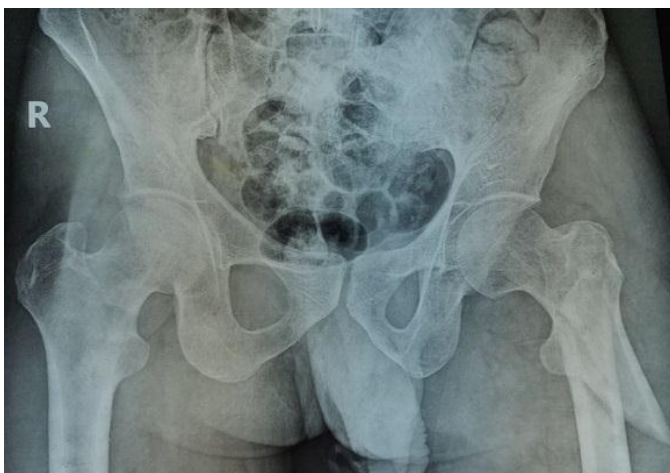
Preoperative X-ray
